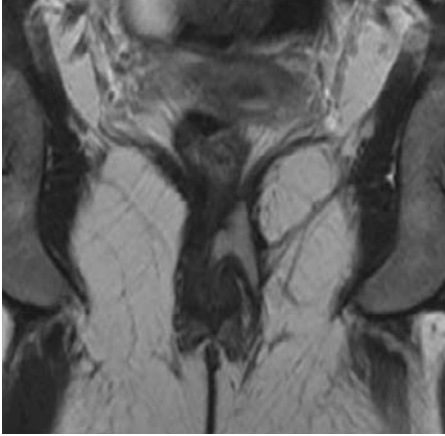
Coronal T2-weighted image with fat saturation. Grade 5 trans-elevator fistula traversing the left ischiorectal fossa
